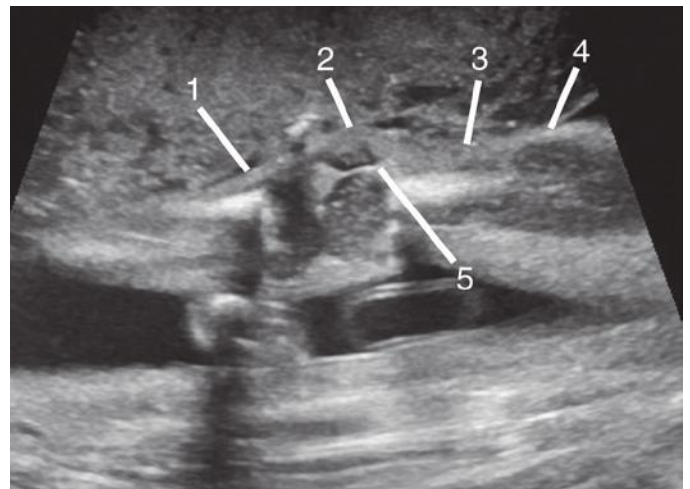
Midsagittal sonogram of the extended knee. In addition to structures pointed out in earlier figures, note the patellar ligament (1), patella (2), quadriceps tendon (3), quadriceps muscle (4), and synovium (5) contained by the knee joint.
